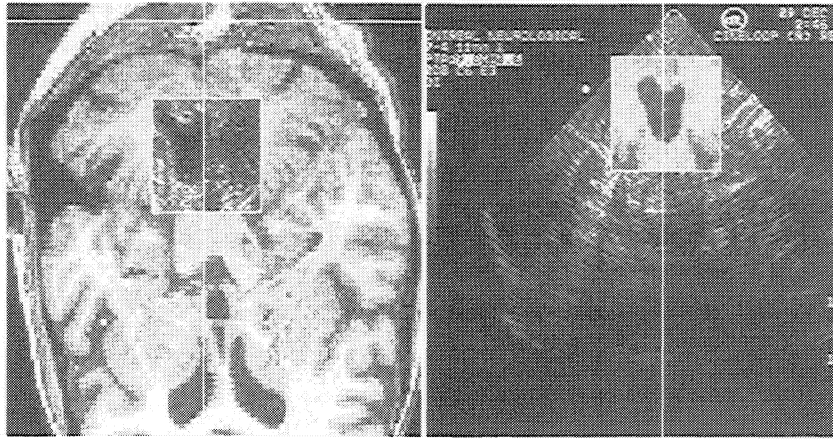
Slice through pre-operative MR image (left) corresponding to the live ultrasound image (right). Note the ROI windows on each image corresponding to information from the other modality.
